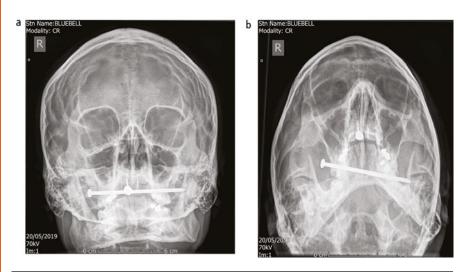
Occipitomental 0 and 30 degree radiographs showing 8 cm nail across maxilla
